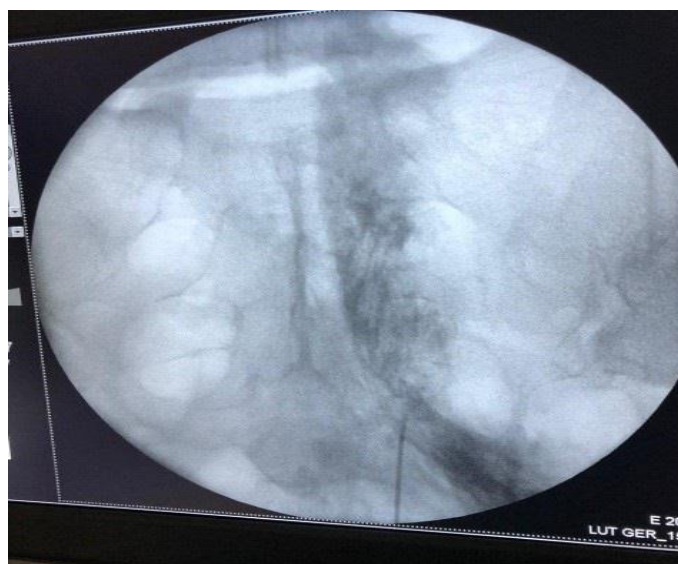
Fluoroscopic image of the ultrasound guided sacral parahiatal approach, showing the dispersion of the contrast solution.
